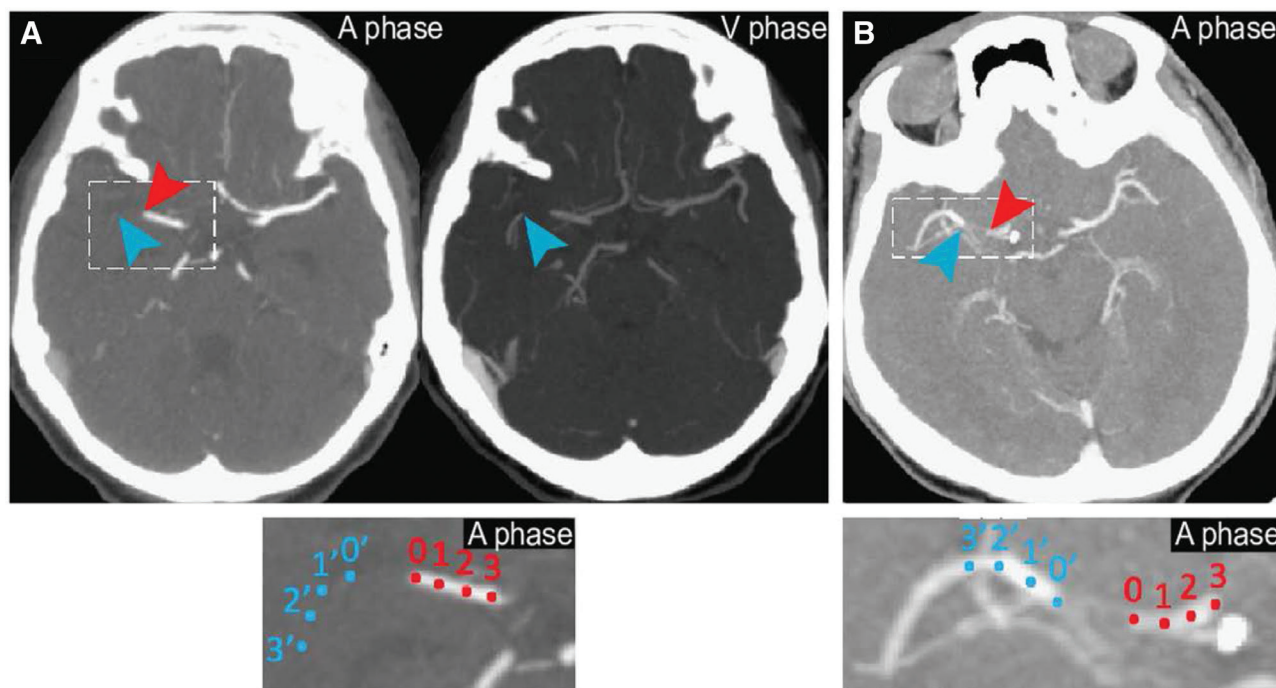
Measurements of the intra-arterial Hounsfield units (HU) (A) at the central point of proximal artery end [HU₀], 1 mm [HU₁], 2 mm [HU₂], and 3 mm [HU₃] (red dots and numbers at high magnification) after determination of the proximal occlusion site in arterial phase (A phase) computed tomography angiography (CTA; red arrow head). When the distal occlusion end could not be identified in the A phase CTA, we manually overlapped the venous phase (V phase) CTA to determine the distal occlusion site (blue arrow head) onto the A phase CTA to measure [HU₀], [HU₁], [HU₂], and [HU₃] (blue dots and numbers). (B) When the distal occlusion site was visible in the A phase CTA, we measured the HU level of the distal occlusion site (blue arrow head) at the distal end [HU₀] and at 1 mm [HU₁], 2 mm [HU₂], and 3 mm [HU₃] (blue dots and numbers).
